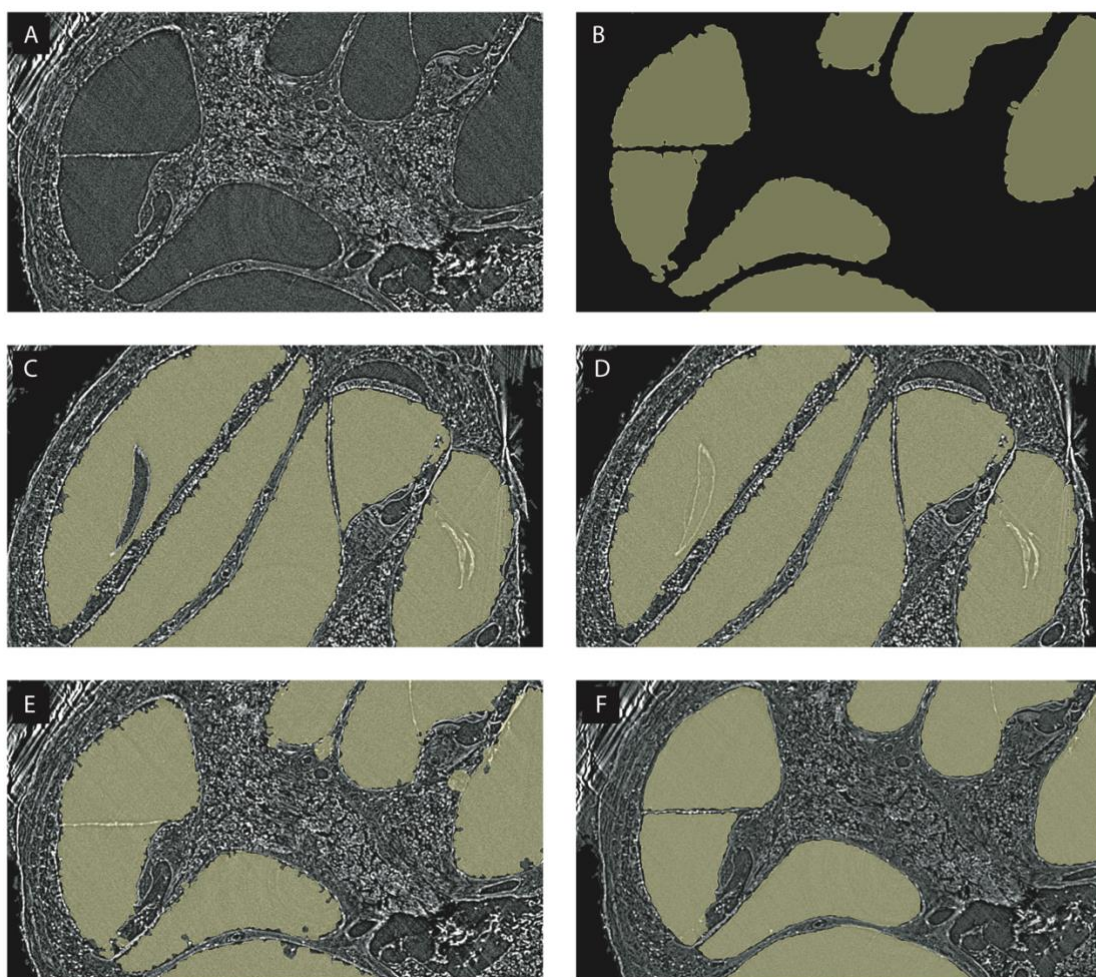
Steps taken to manually edit and segment X-ray μ CT image slices
